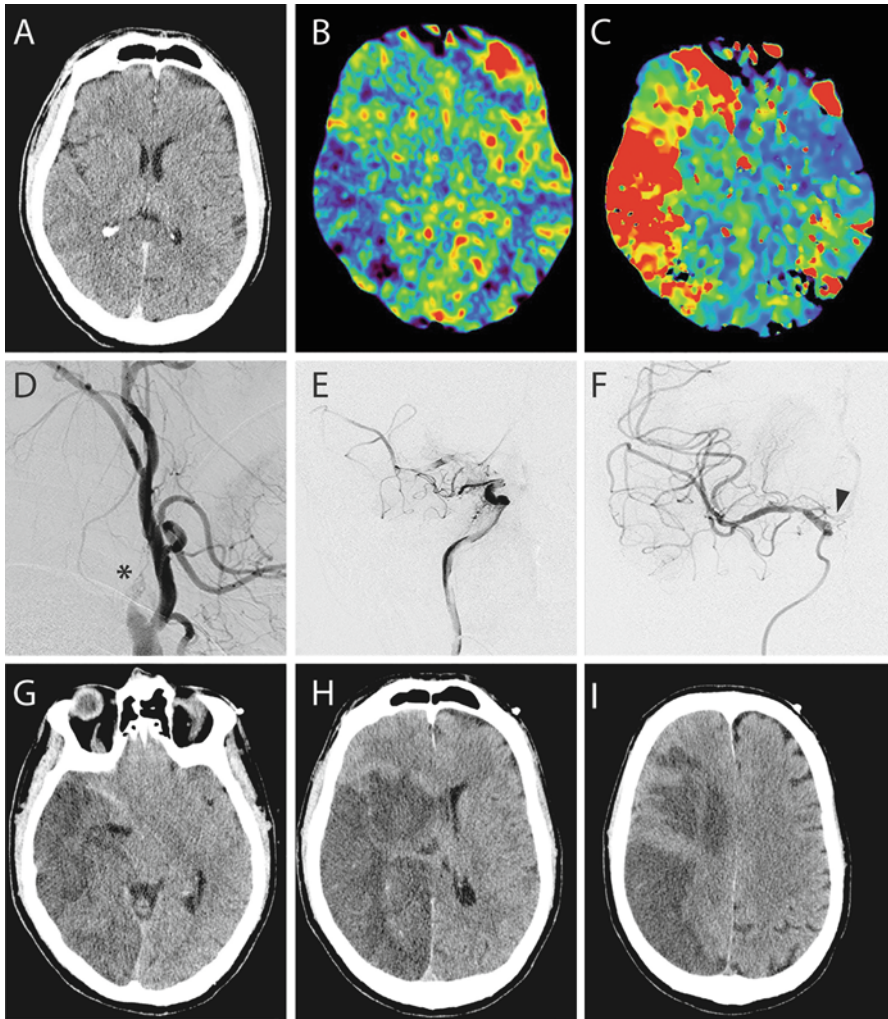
Intra-arterial and mechanical thrombolysis for acute stroke. This 36-year-old female presented 4 h after acute onset arm and facial weakness with dysarthria. (a) Initial CT scan demonstrated early ischemic changes in the right MCA distribution. (b, c) CT perfusion demonstrated decreased cerebral blood flow (b) and elevated time to peak concentration (c) in the right MCA distribution. The patient received 0.6 mg/kg of rtPA and was taken to angiography. (d) Angiogram revealed an occlusion of the right internal carotid artery (*asterisk*). (e) A Penumbra device was used to aspirate clot from the internal carotid artery and achieve reperfusion. (f) Intra-arterial rtPA was infused through a microcatheter (catheter tip at *black arrow*) to achieve recanalization of the MCA. (g–i) The patient did not have neurological recovery following recanalization and went on to have a completed stroke in the right MCA distribution as demonstrated by hypodensity on plain CT 24 h after rtPA. Early uncal herniation (g) and midline shift (h) were evident
